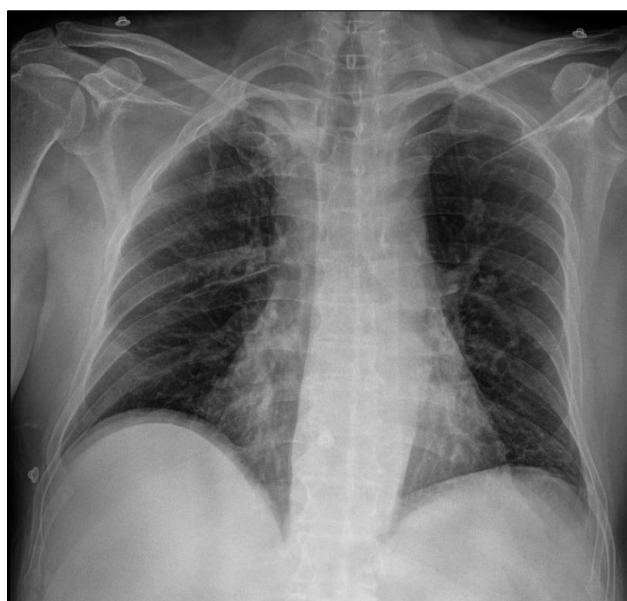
Posteroanterior chest X-ray: A right apical ovoid lesion with irregular, partially defined radiopaque borders and a radiolucent center
